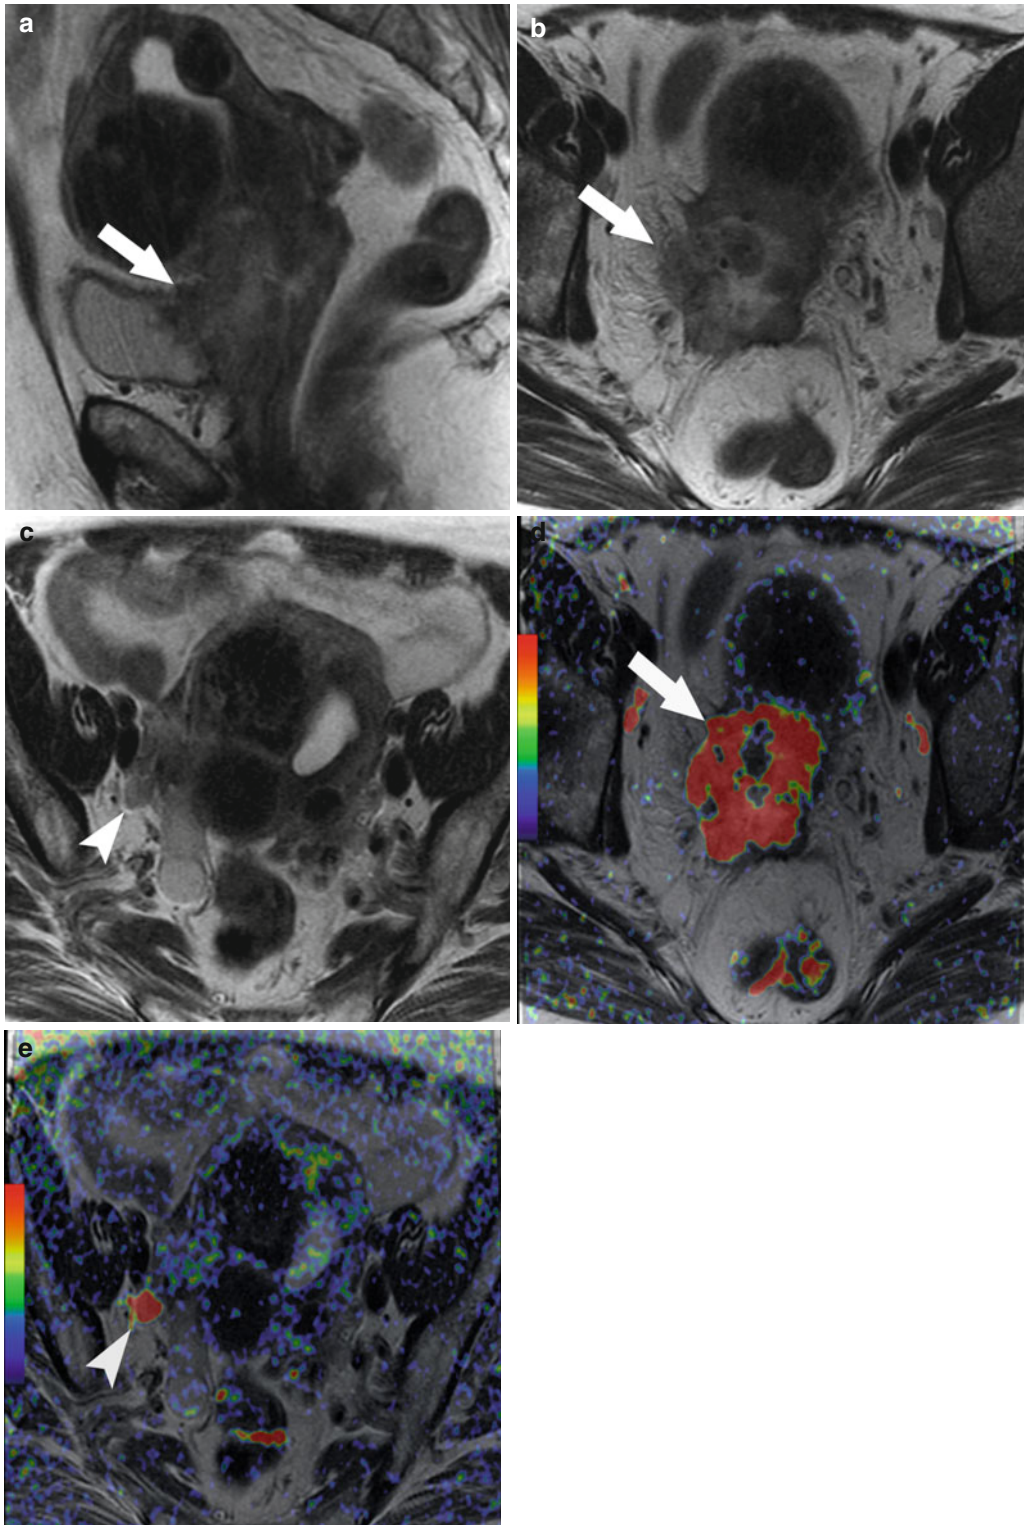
Forty-four-year-old woman with stage IVA cervical cancer with pelvic lymph node metastasis. Sagittal (a) and axial (b, c) T2-weighted images demonstrate the tumor (arrow) invading the posterior bladder wall and an
